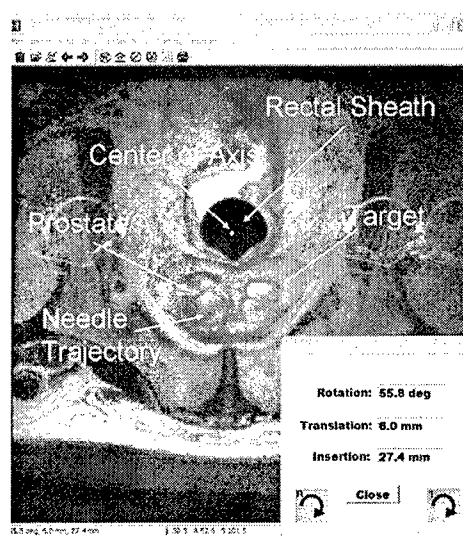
Screen shot of the visualization and targeting program. An axial T2 weighted MR image containing prostate and rectal sheath is displayed. Intersection points of the device axis and the needle trajectory with the MRI image are visualized as well as the selected target point. The necessary rotation, translation, and insertion values to reach the target are displayed in the lower right corner.
